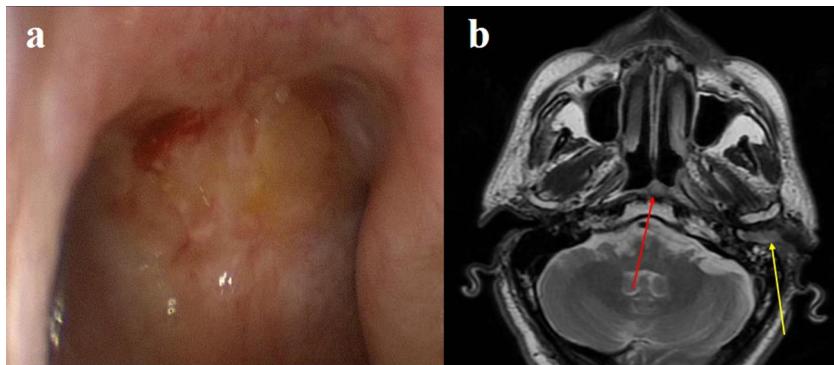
(a) Small recurrence at the nasopharyngeal postero-superior wall (rT1). (b) The MRI shows the superficial nasopharyngeal recurrence (red arrow) and a second primary tumor at the external auditory canal (yellow arrow).
